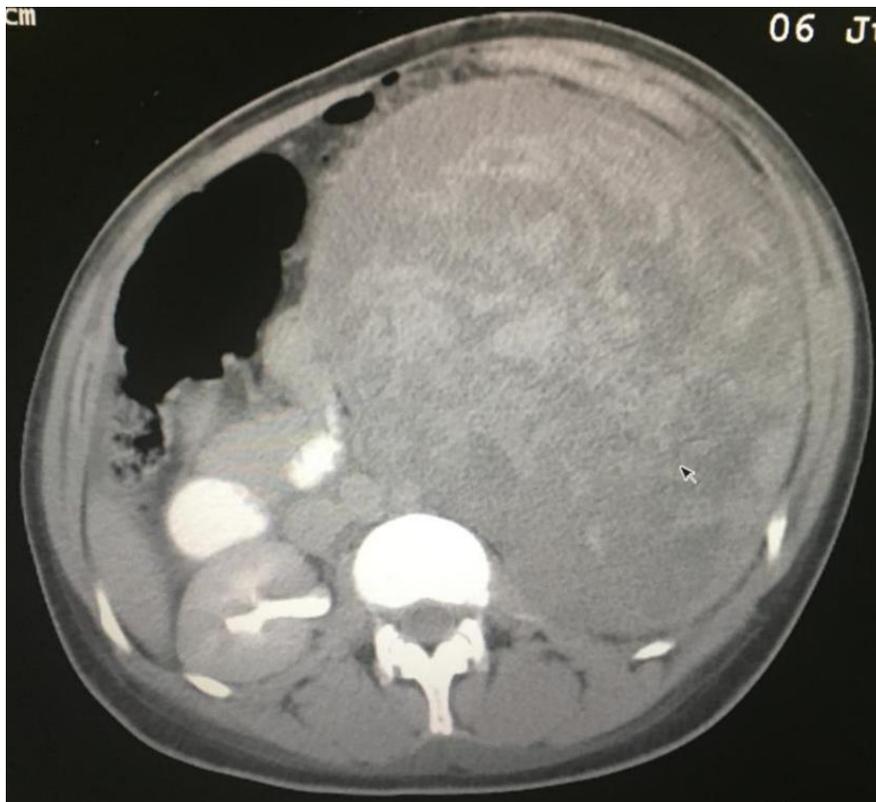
Axial CT scan of the abdomen showing a soft tissue mass arising from the left kidney
